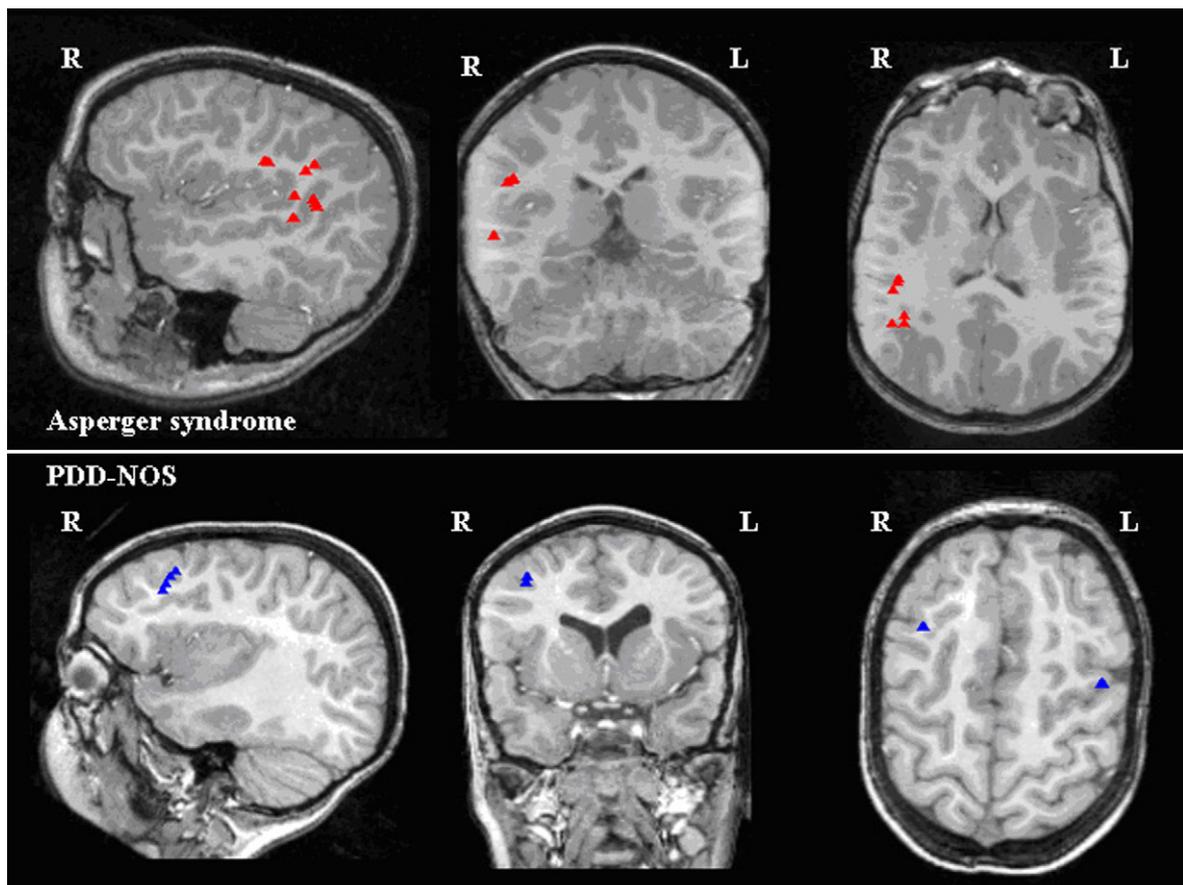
Representation of MEG dipoles on MRI scans in a case of Asperger’s syndrome compared with PDD-NOS (triangles: paroxysmal rhythmic activity dipoles).
